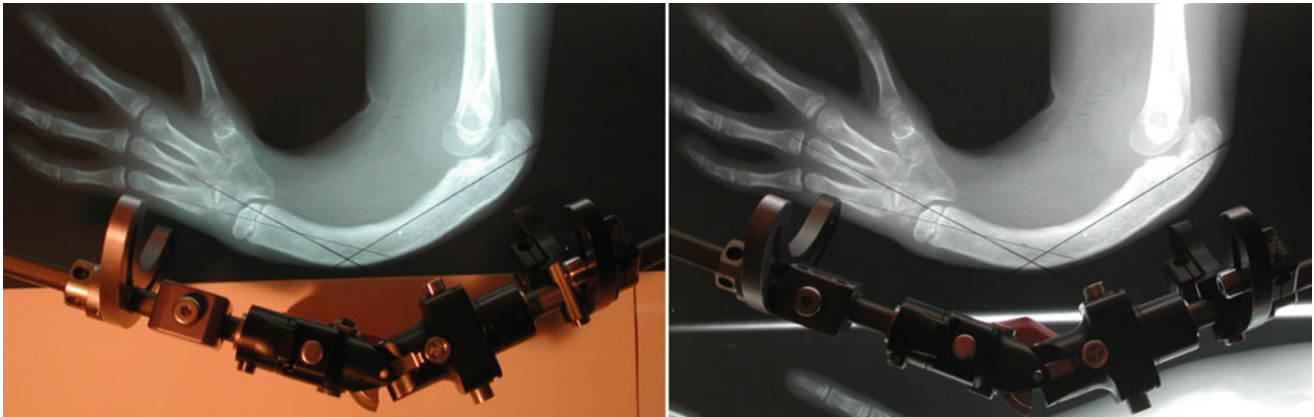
Preconstruction of the external fixator based on preoperative radiographs
